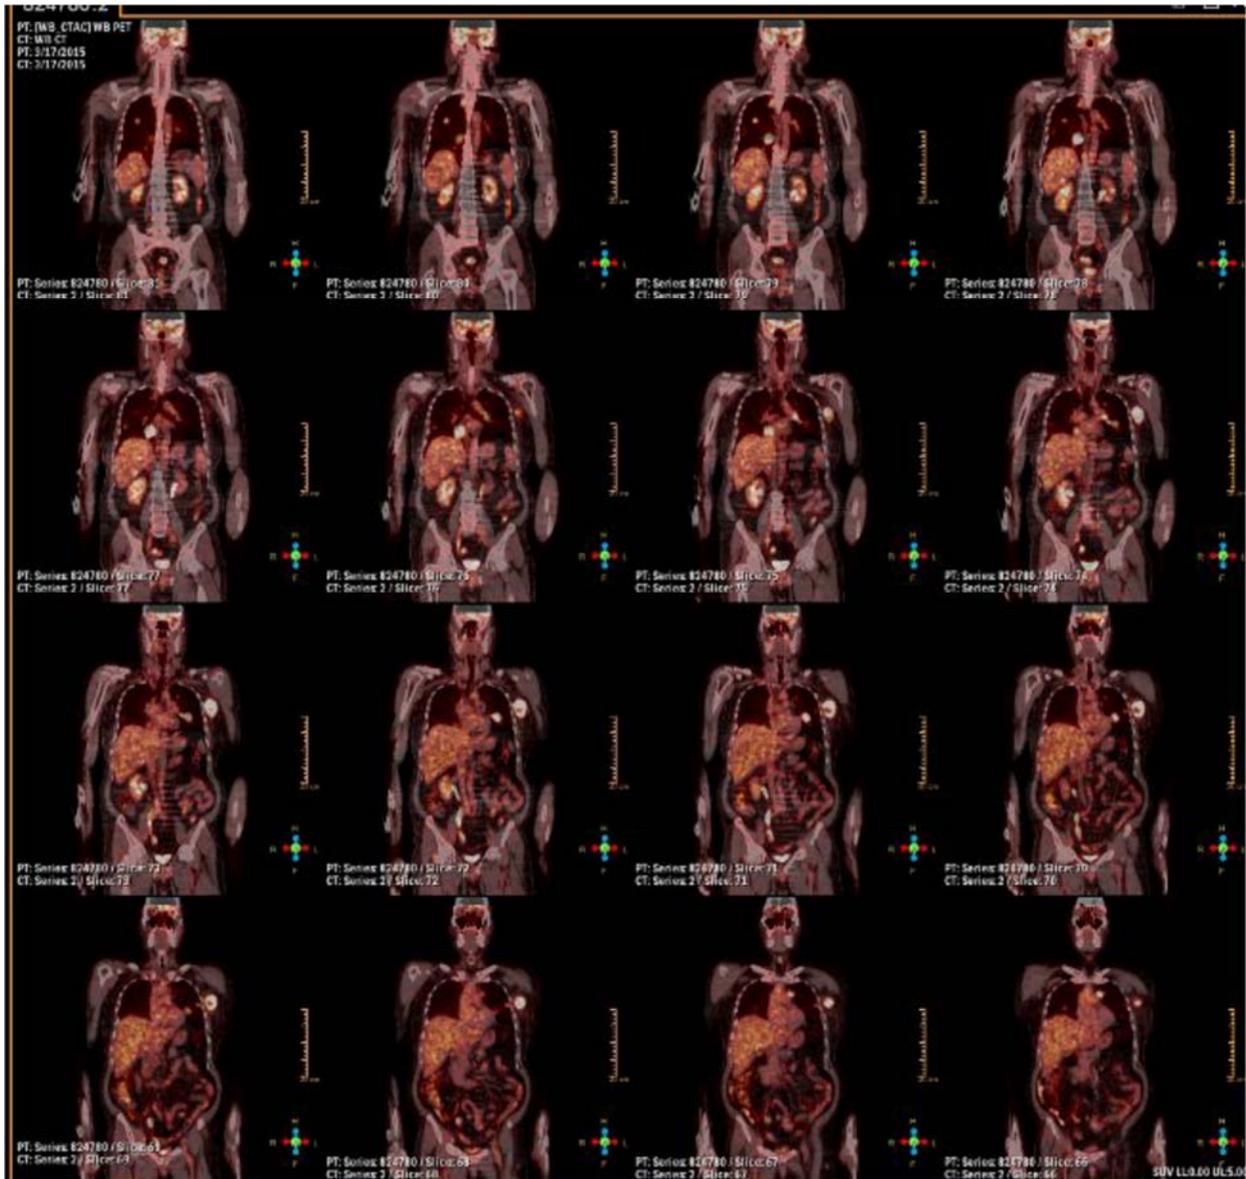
18F-FDG-PET/CT (MIP and multiple coronals) showing multiple 18F-FDG avid well defined lesions in bilateral lung parenchyma (largest in the left lower lobe measuring 4.2 x 2.8 cm and SUVmax of 14.38), soft tissue mass in left axilla (SUVmax 13.31), subcutaneous nodule in right anterior abdomen (SUVmax 5.82) and sclerotic lesion in right iliac bone (SUVmax 7.40).
